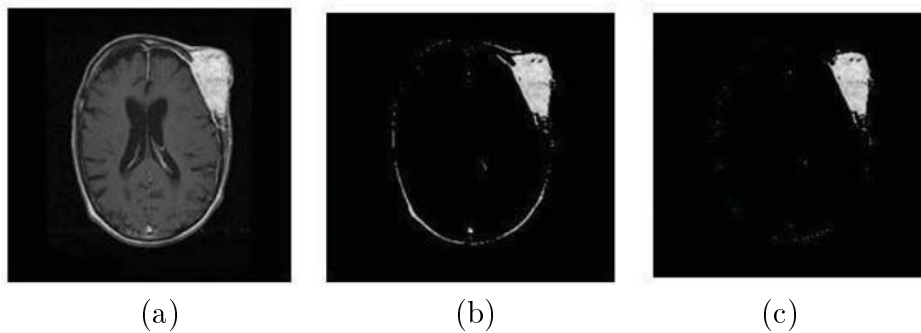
Patient dataset-2: (a) original un-segmented brain MRI, (b) optimized MRI image using HPSOWM, (c) segmentation using the proposed method
